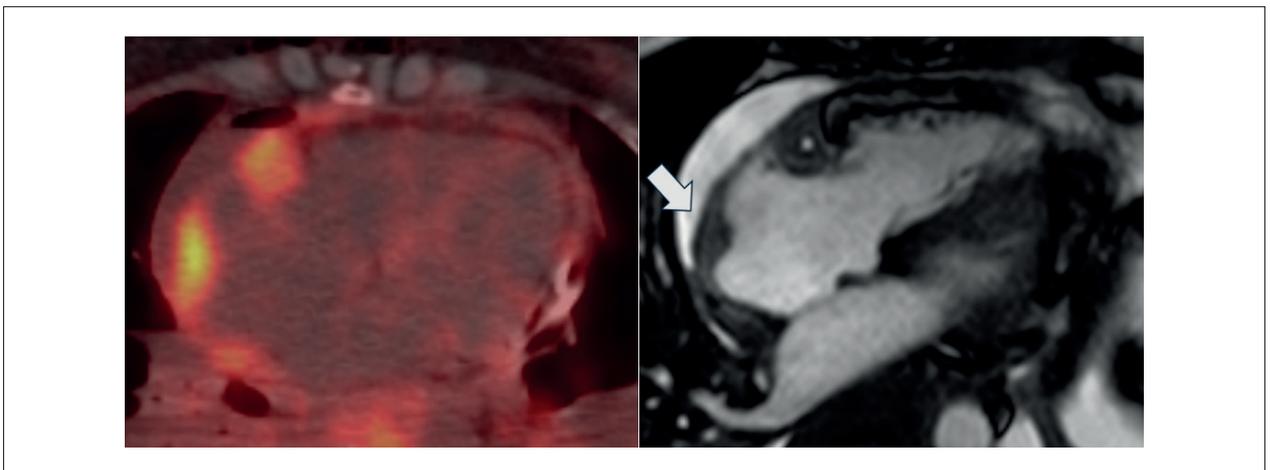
PET-CT fusion imaging (left) demonstrated tissue with glycolytic hypermetabolism in the walls of the right atrium and the right atrioventricular sulcus, with extensive involvement of the right coronary artery. The same findings were observed in the cine-resonance on the right (white arrow pointing to thickening of the free wall of the right atrium). Taken together with systemic findings (bone, lung, abdominal, head and neck), diagnosis of Erdheim-Chester disease was made. CT: computed tomography; PET: positron emission tomography.
